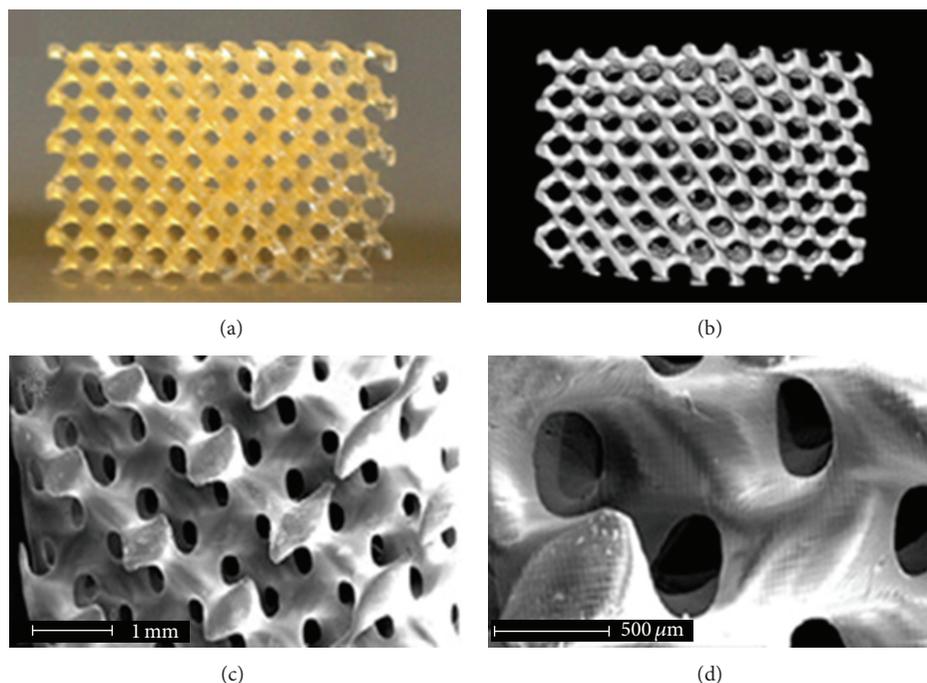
Photograph (a), μ CT visualization (b), and SEM images ((c) and (d)) of a scaffold built by SLA using PCL macromere (the targeted theoretical molecular weights (M_n) of which was 1500 g/mol) [65].
